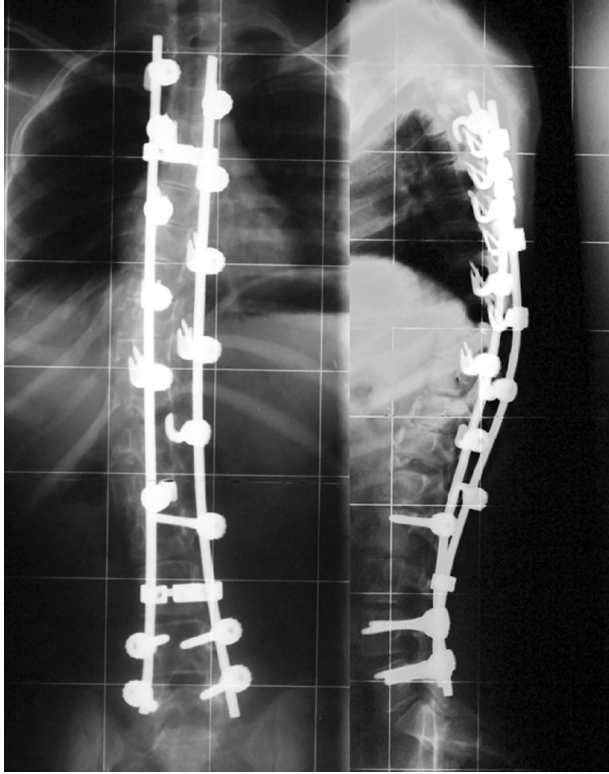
The anterior-posterior and lateral postoperative x-rays at the time of reexamination 4 years after surgery showed a significant reduced right convex thoracolumbar scoliosis to a 24-degree Cobb angle (Th8-L3). In the lateral view, kyphosis angles were 32 degrees between Th4 and Th12.
